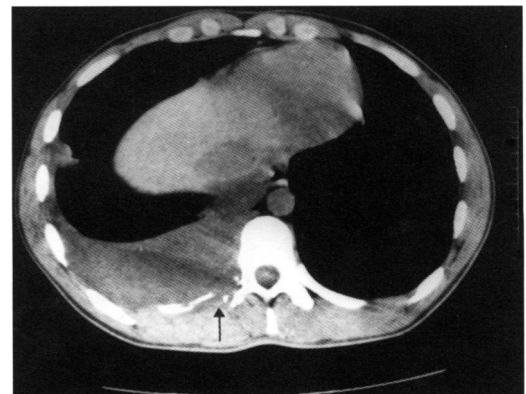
Computed tomographic scan showing pleural effusion and partial destruction of the right 11th rib (arrowed) and adjacent vertebral body.
